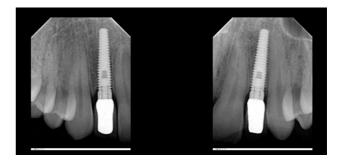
Periapical radiographs 3.5 years post-treatment.
